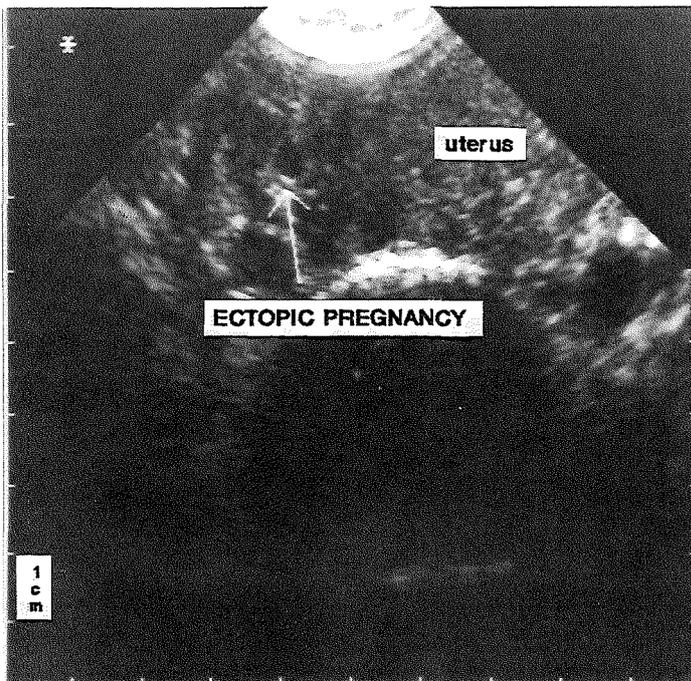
Sonographic appearance of a non-vital ectopic pregnancy (Patient No. 10).
